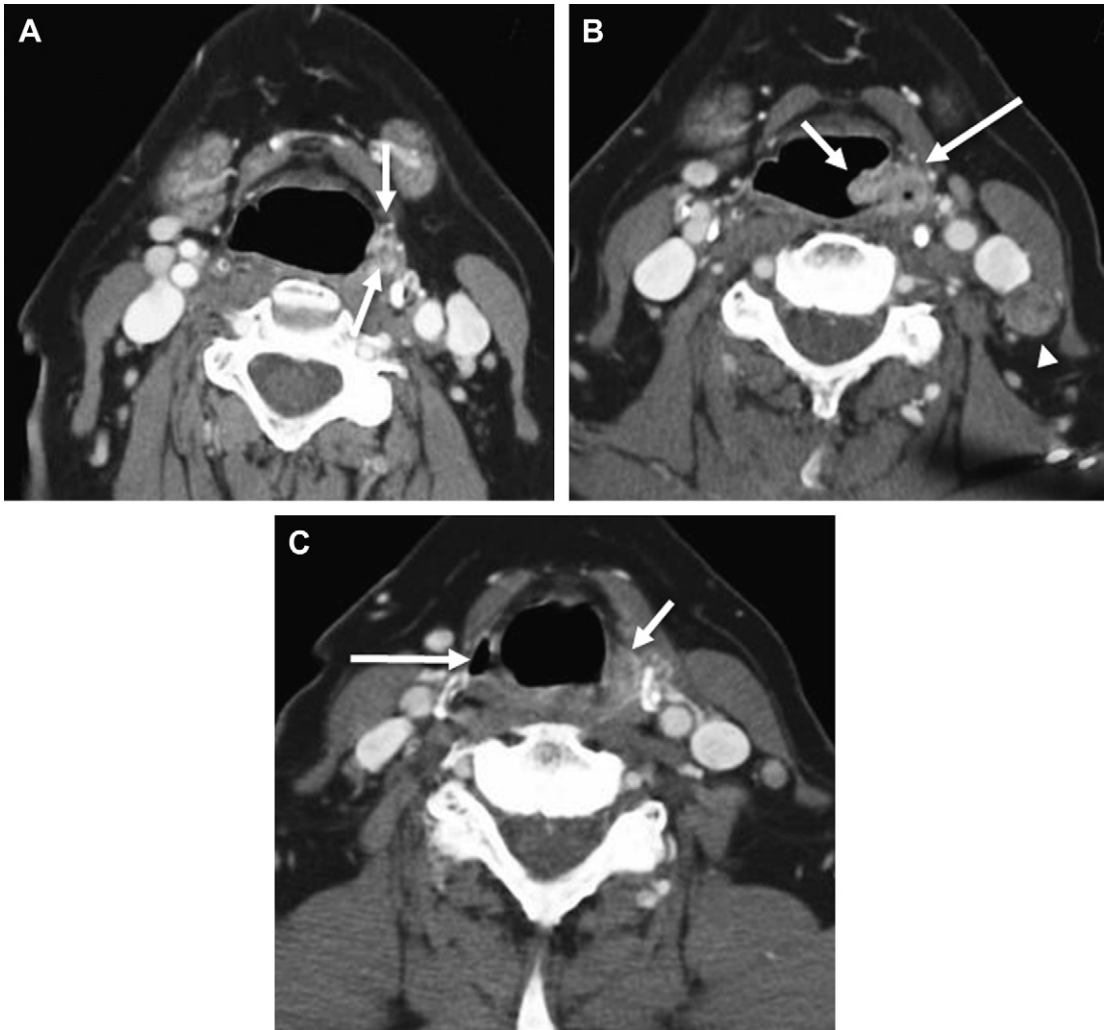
T1 pyriform sinus SCC on left, missed on initial image interpretation. (A) Axial contrast-enhanced computed tomography (CECT) shows left SCC (<2 cm) at the superior pyriform sinus (arrows). This study was interpreted as “Normal neck CT. No tumor.” (B) Axial CECT obtained 16 months after A shows increase in size of the mass filling the pyriform sinus, and involvement of the laryngeal surface of the left aryepiglottic fold (AEF) (arrow). Note extension to the posterior paraglottic fat (long arrow). Posterior left level III node is now larger with unequivocal necrosis (arrowhead). (C) Axial CECT at low pyriform sinus level shows normal right air-filled sinus (long arrow). Note tumor in left pyriform sinus (short arrow). On subsequent images tumor was present in the apex of the sinus, a finding that was not present on the initial study. Pyriform apex involvement carries a poor prognosis when compared with tumor only at the superior aspect of the pyriform sinus.
